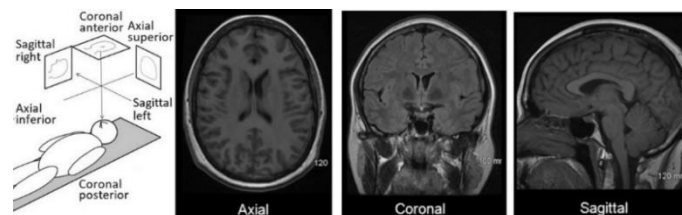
Example of the MRI Slices of the Axial, Sagittal, And Coronal Planes (Avots, Jafari, Ozcinar, & Anbarjafari, 2024)
